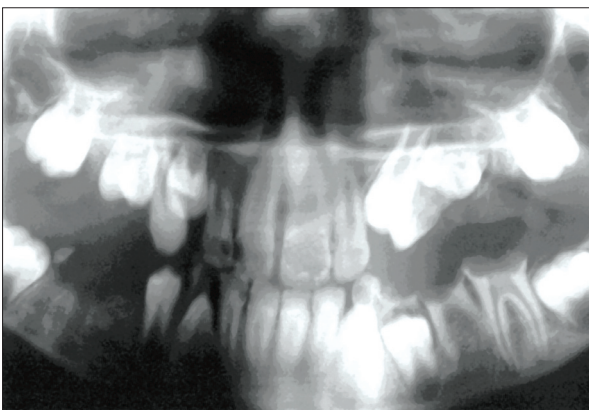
The intra-oral radiographical view of the patient.
